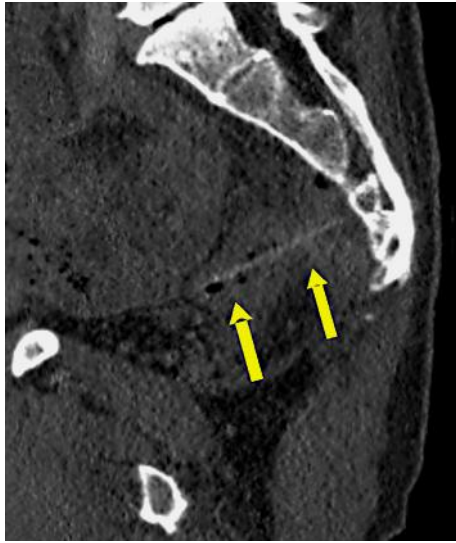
CT scan showing a rectal perforation caused by a foreign body. The arrows indicate the toothpick perforating the rectum.
